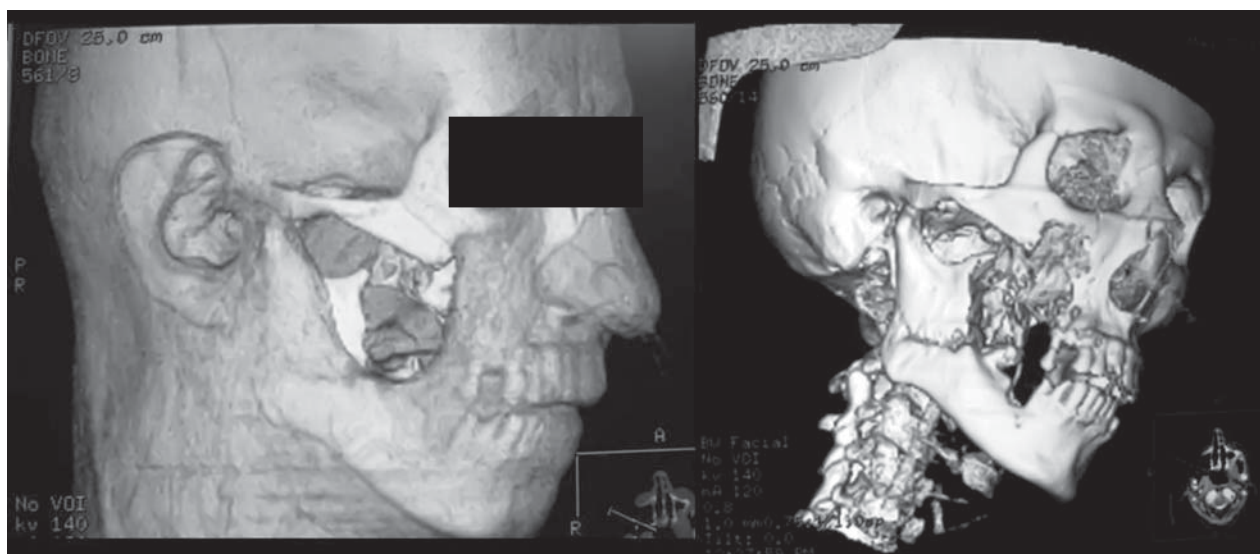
Three dimensional volumetric computed tomography with soft tissue and bone algorithms of the maxillofacial region.
